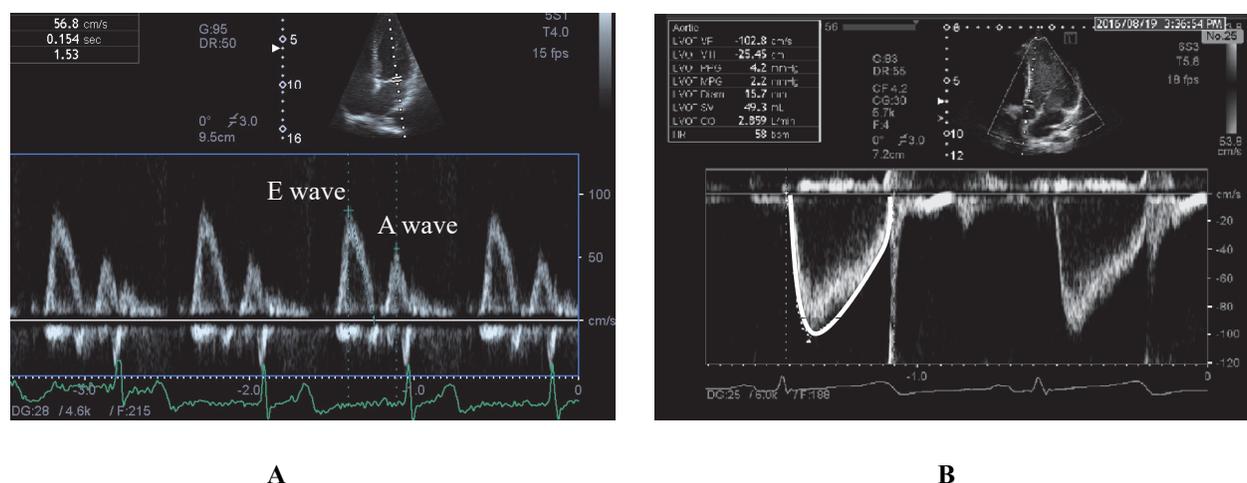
Cardiac parameters recorded with a pulsed-wave doppler.
